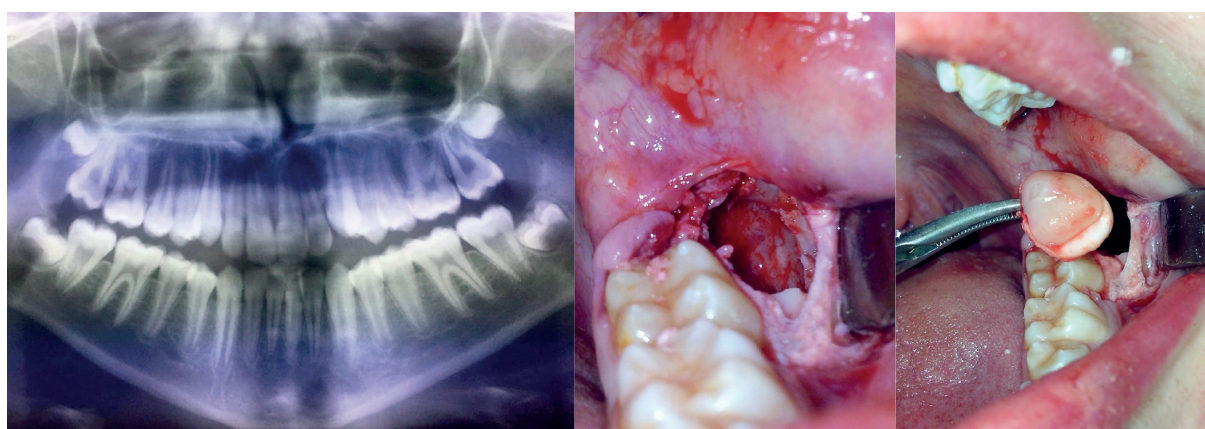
A-C. Clinical Images. (A) Orthopantomogram of the site before treatment. (B) After the alveolar bone was removed by a periosteal detacher, the tooth socket was exposed and (C) delivered in mesiolvestibular direction by inserting a straight elevator.
